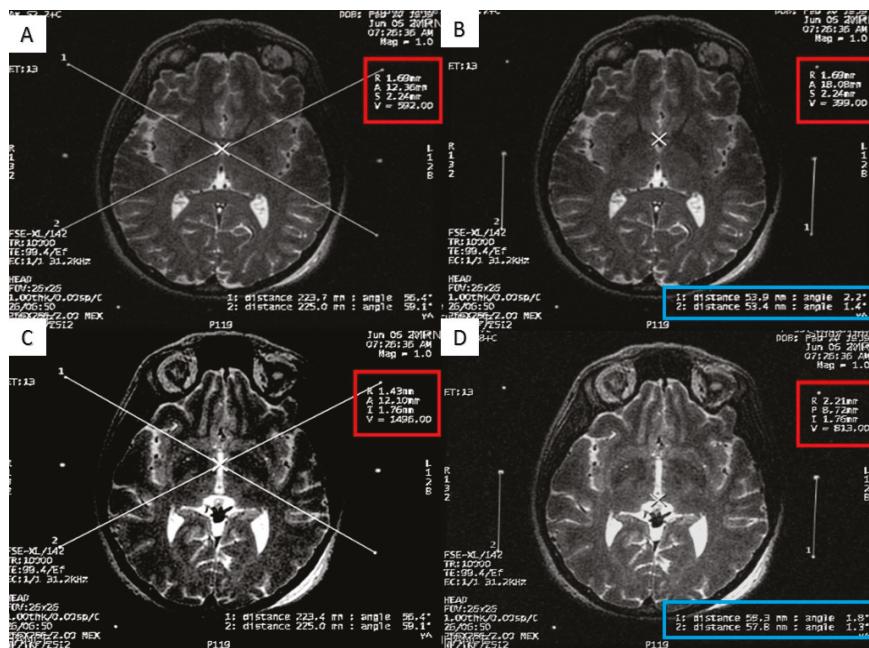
Calculating the anterior commissure (AC) and posterior commissure (PC) coordinates using the magnetic resonance scanner console. (A) Two diagonal lines intersecting at the center of the frame at the AC level with the magnetic resonance imaging (MRI) coordinates of the center of the frame shown inside the red square; (B) a crosshair at the posterior margin of the AC, with the MRI coordinates of the AC shown inside the red square. Two lines are drawn between the middle and the lower fiducials on both sides of the frame and their lengths (in the blue rectangle) are used to calculate the Z coordinate of the AC; (C) two diagonal lines intersecting at the center of the frame at the PC level with the MRI coordinates of the center of the frame shown inside the red square; (D) a crosshair at the anterior margin of the PC, with the MRI coordinates of the PC shown inside the red square. Two lines are drawn between the middle and the lower fiducials on both sides of the frame and their lengths (in the blue rectangle) are used to calculate the Z coordinates of the PC.
